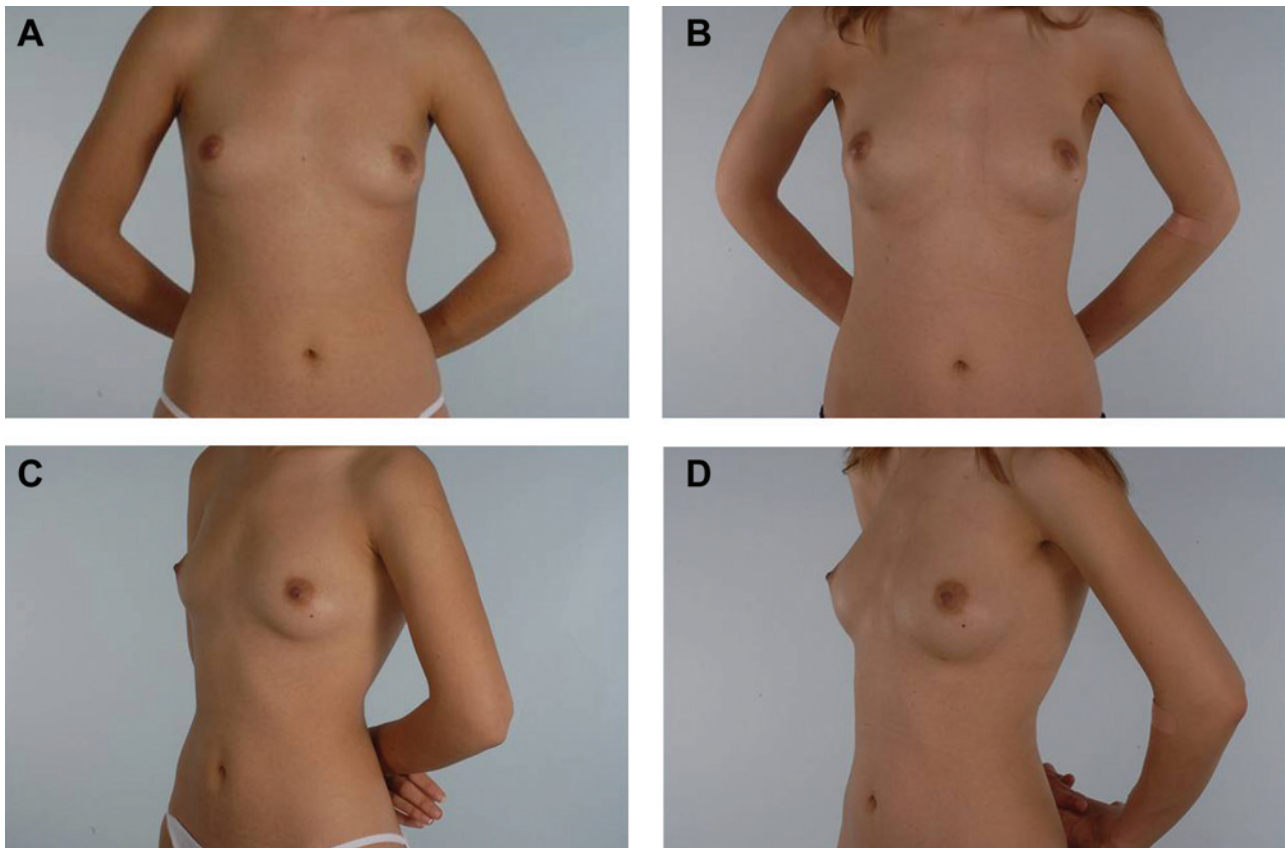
(A, C) This 24-year-old woman presented for lipoaugmentation of the breast. (B, D) One year after the procedure, in which total lipoaspirate was 1000 cc, yielding 540 cc of graftable fat (54%) with 280 cc of fat injected into the right breast and 260 cc injected into the left. It was not possible to obtain postoperative VECTRA data on this patient due to poor calibration of the images. Magnetic resonance imaging measurements revealed a 14.3-cc volume increase in the right breast and a 11.2-cc increase on the left. This patient was judged as having moderate improvement by the observers.
